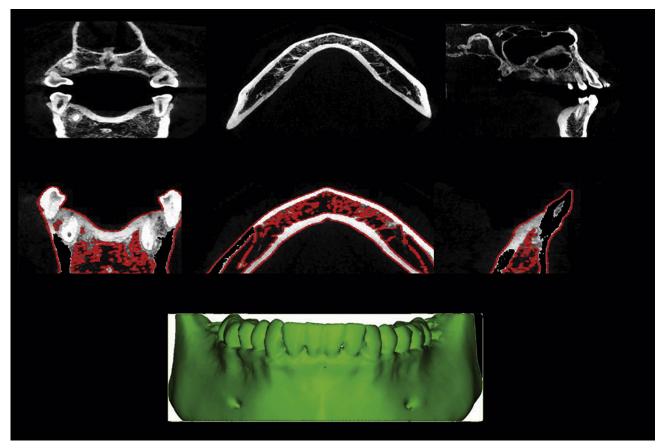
Segmentation and reconstruction of CBCT-derived mandibular cast. CBCT, cone beam computed tomography.
